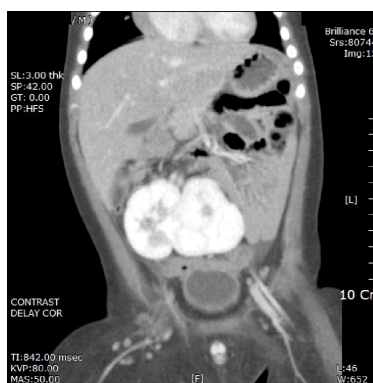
Enhanced computed tomography showing right crossed fused renal ectopia located in the pelvis.
